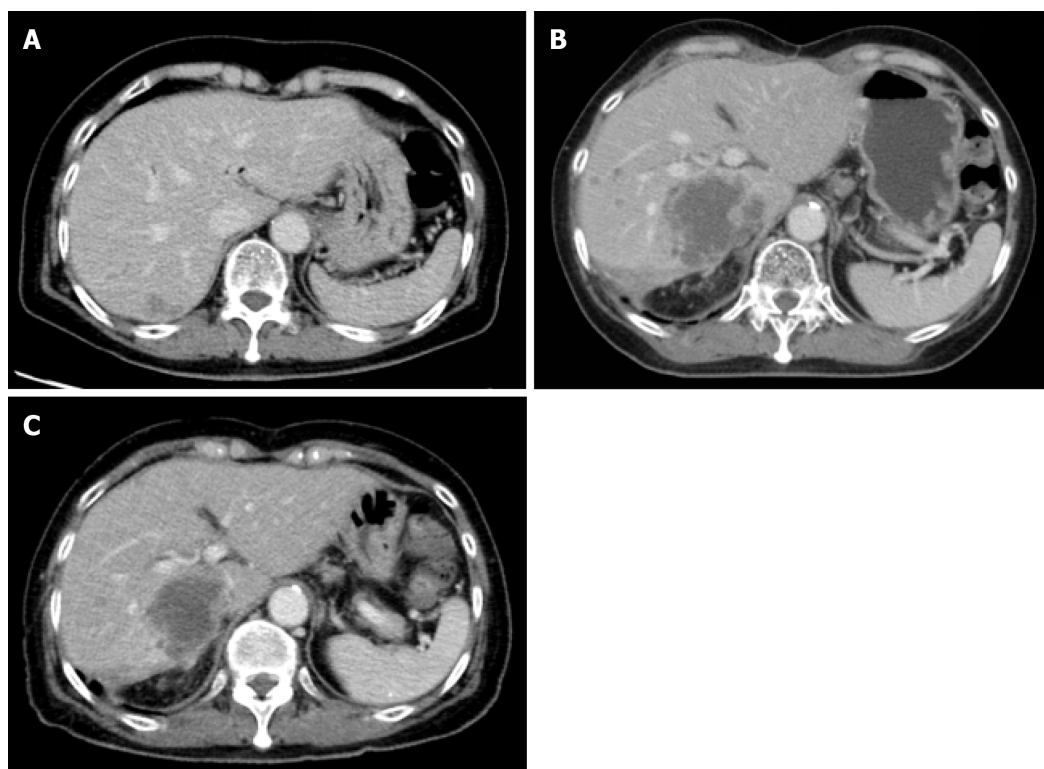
Contrast computed tomography images. A: Contrast computed tomography scan before surgical biopsy. A hypoattenuating lesion with ill-defined margins was observed in the posterior lobe of the liver; B and C: Comparative contrasted computed tomography scan before (B), and after (C) 2 cycles of lapatinib and capecitabine treatment. Hepatic metastases were reduced in size and tumor emboli in inferior vena cava (arrow heads) was mostly disappeared with the therapy.
